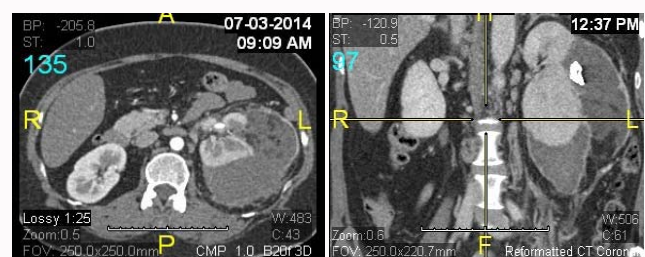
CT abdomen showed angiomyolipoma at midpole of left kidney, measuring 3.8cm x 3.9cm x 4.7cm. There was large perinephric hematoma.
